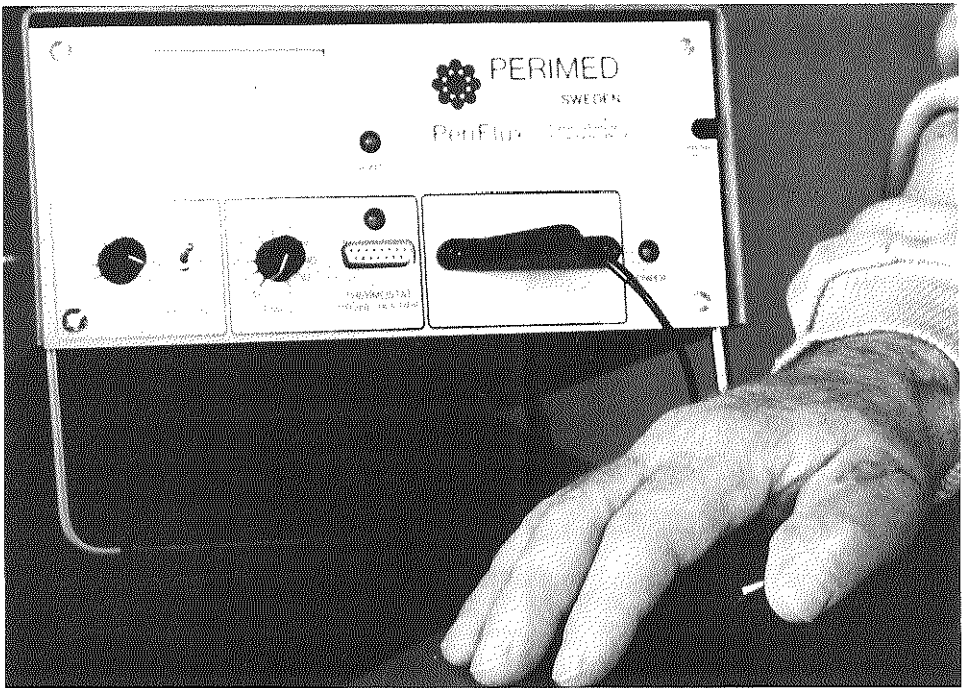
The skin blood flow of a replanted thumb monitored by a laser Doppler flowmeter.
